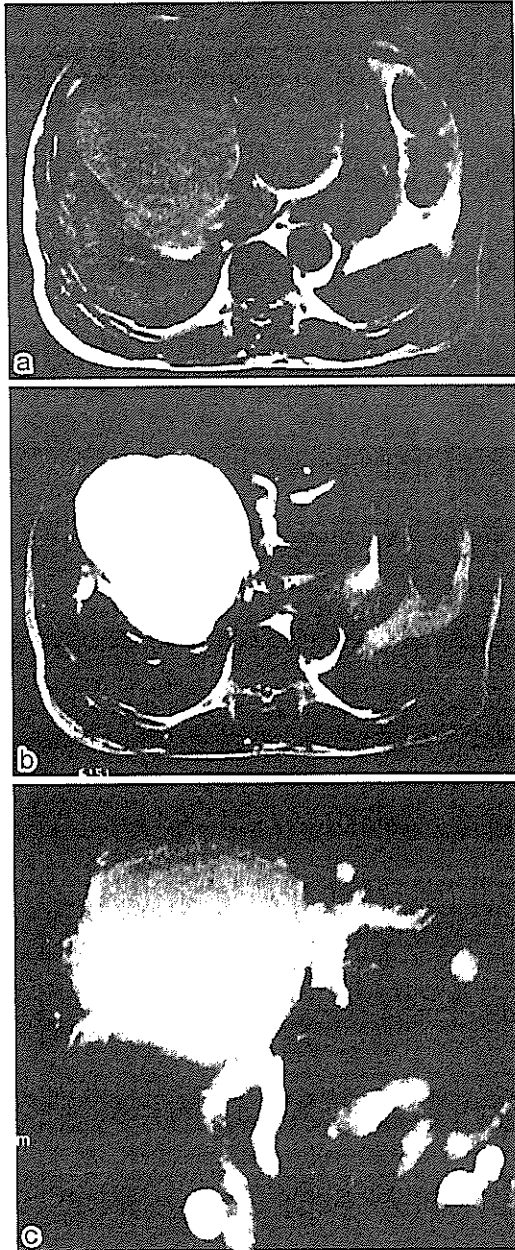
Abdominal magnetic resonance imaging. a: T1-weighted imaging shows a cystic lesion with homogeneous high signal intensity. b: T2-weighted imaging also shows homogeneous high signal intensity. c: Magnetic resonance cholangio-pancreatography indicates the presence of a large spherical lesion near the confluence of the right and left hepatic ducts that is compressing the intrahepatic bile ducts and keeping them separate from the common bile duct.
